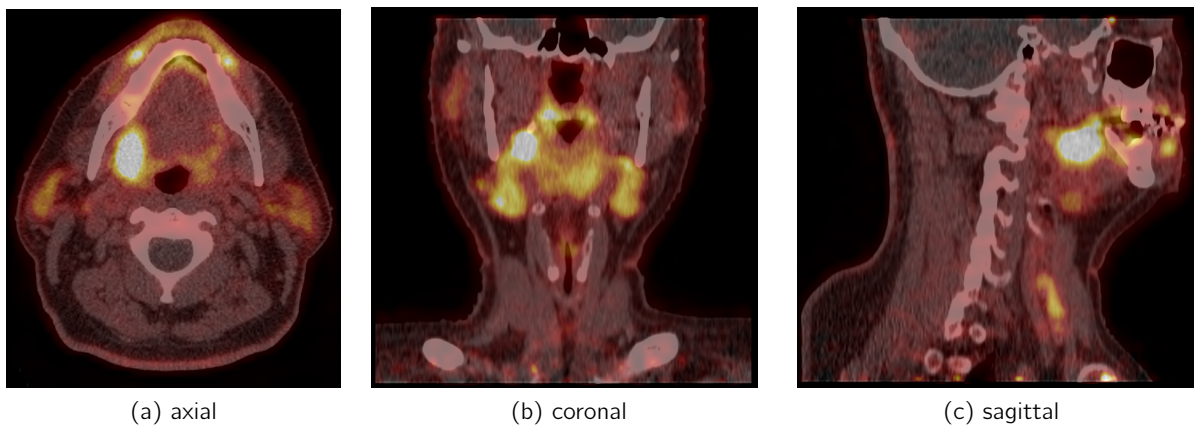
The tumour in the right tonsil loge in three different views on follow-up RGD PET with a low-dose CT
